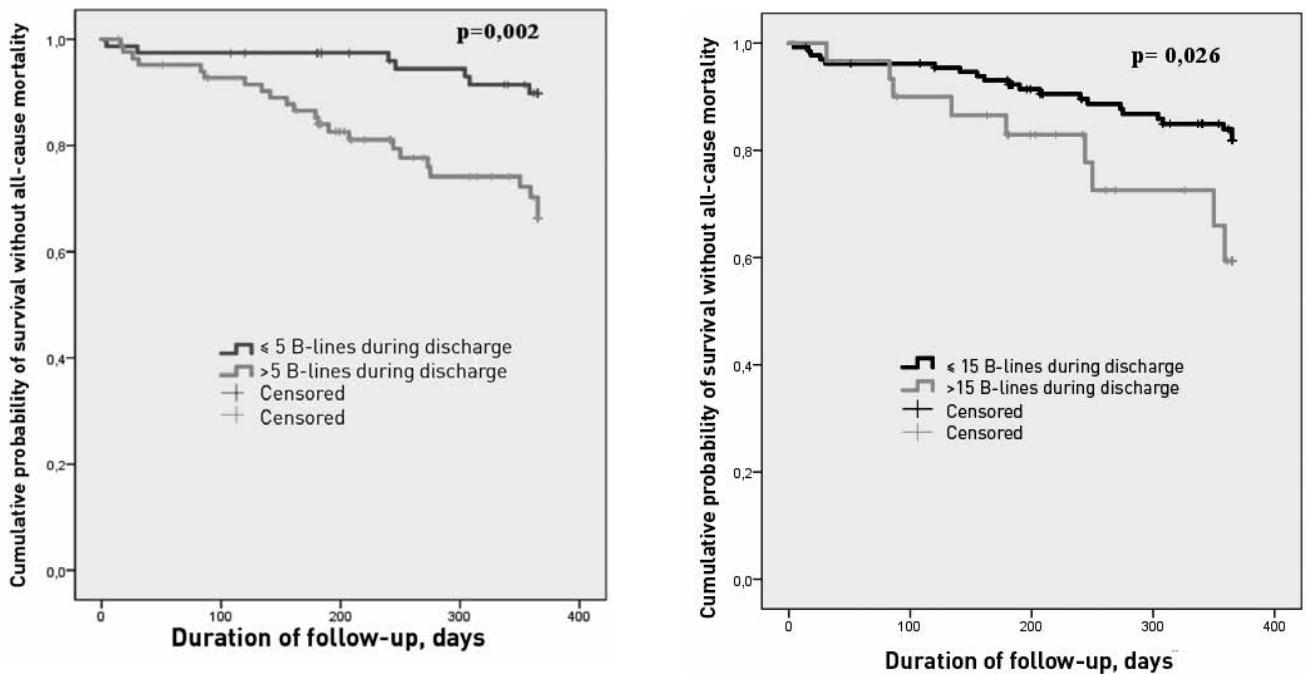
Kaplan Meier curves for cumulative probability of survival (without all-cause mortality) depending on the presence and severity of lung congestion according to lung ultrasound during discharge.
